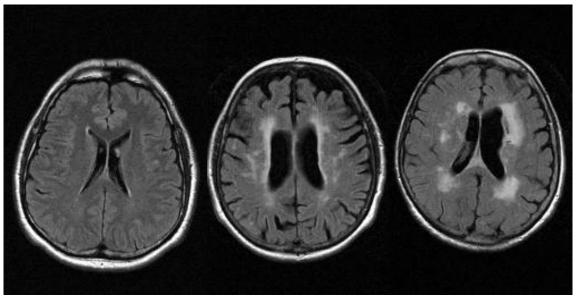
White matter hyperintensities on routine FLAIR imaging in 3 subjects at the age of 70. On the left a normal finding is shown with only solitary lesions, in the middle a mixed stage with solitary and partially confluencing lesions. The case on the right represents major confluencing lesions mixed with makroangiopathic changes hydrocephalus e vacuo.
